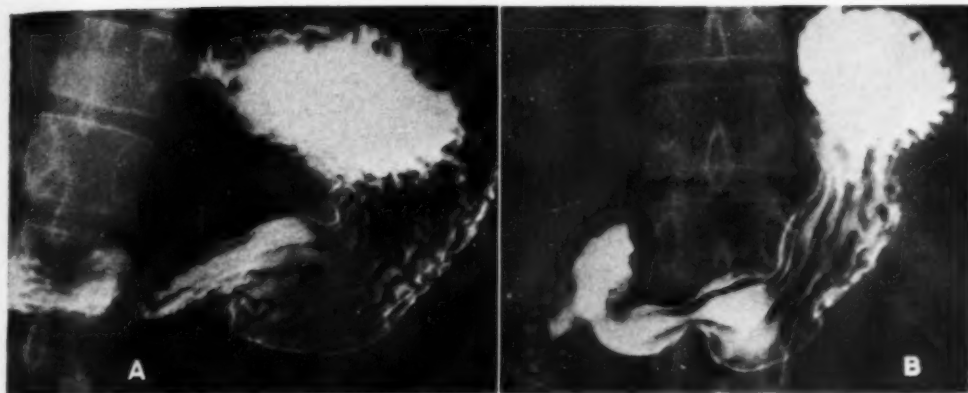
A and B. Roentgenograms of two different individuals to show variations of normal fold pattern.
